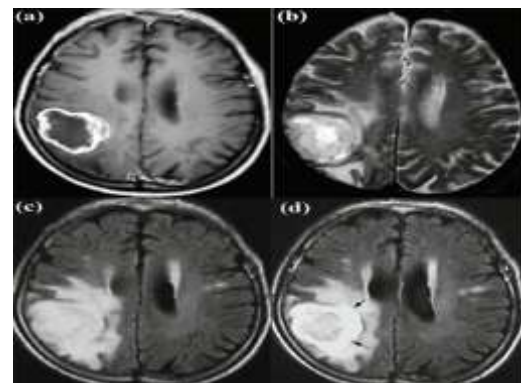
Four different MRI modalities showing high grade gliomas, each enhancing different sub regions of the tumor.
